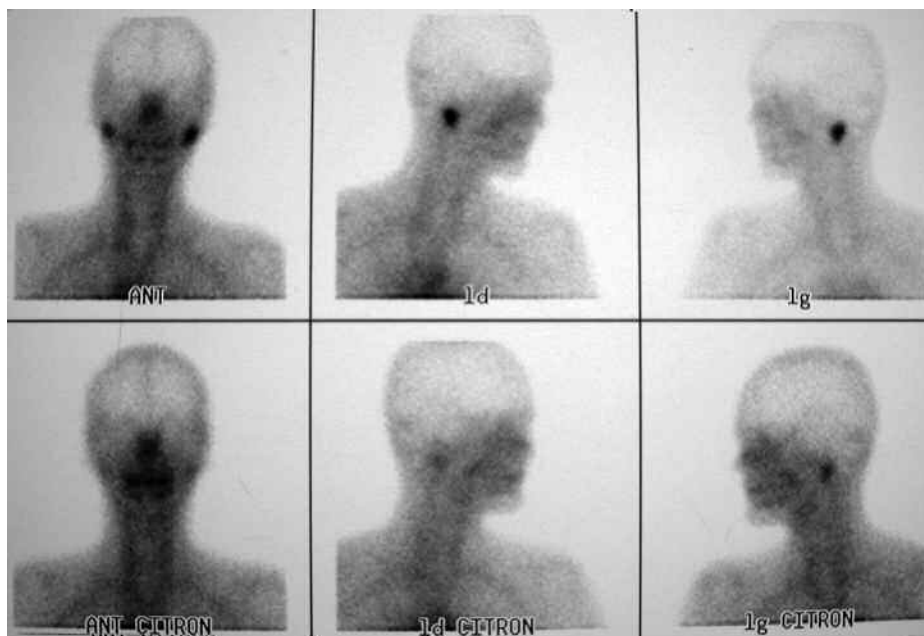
Patient's Tc⁹⁹ salivary scintigraphy: note the absence of caption of the radiotracer at the level of the sub-maxillary and sublingual glands and the reduced caption of both parotid glands (upper row). A certain delay in eliminating the radiotracer is noticeable at the level of the left parotid following lemon intake (lower row). In addition, note that the thyroid gland is not functional.
